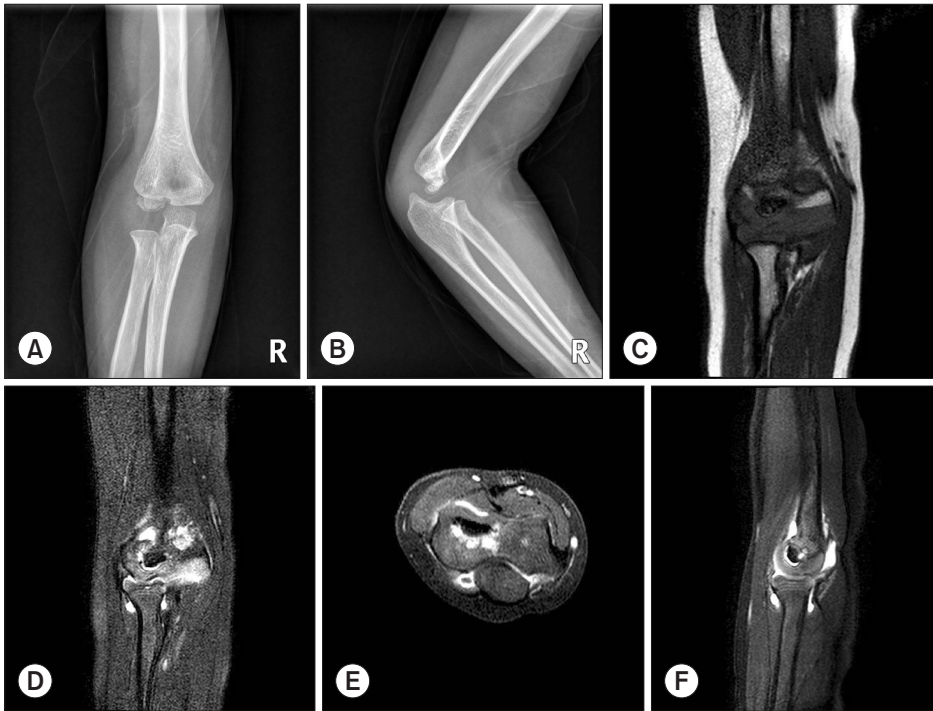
Initial radiographic examination of the 5-year-old male patient. (A, B) Sclerosis within the capitellar ossification center is seen on this anteroposterior and lateral plain radiographs. (C, D) A T1-weighted and a T2-weighted fat suppressed coronal image show a dark signal throughout the capitellum. (E, F) A T1-weighted fat suppressed axial and a T2-weighted fat suppressed sagittal images show decreased signal throughout the capitellum. The overlying articular cartilage appears intact with smooth articular surface.
